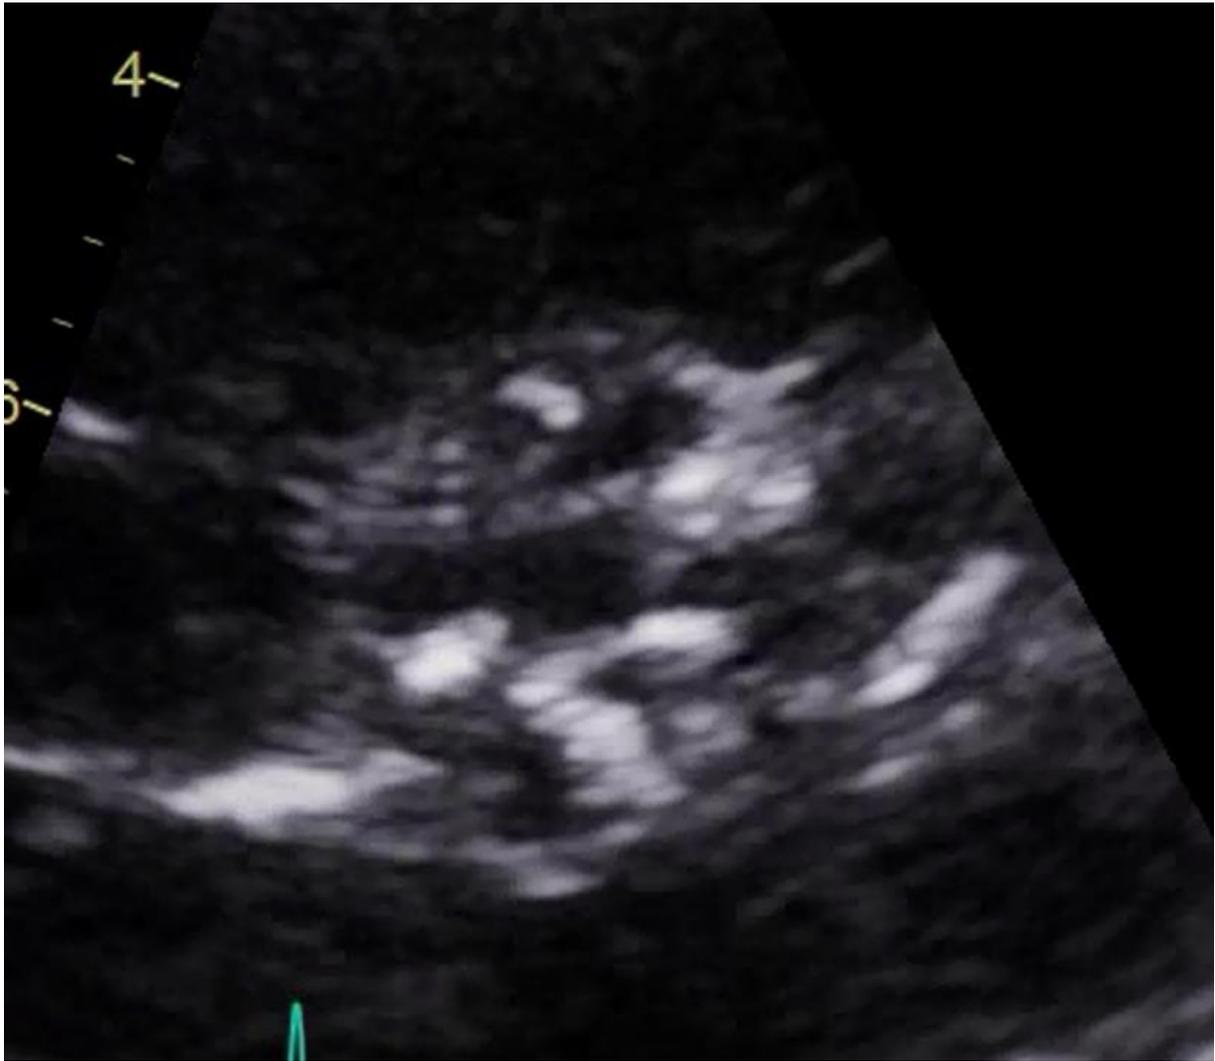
Peak excursion of Aortic Valve during dobutamine stress echocardiogram demonstrating calcified aortic valve; short axis view.
